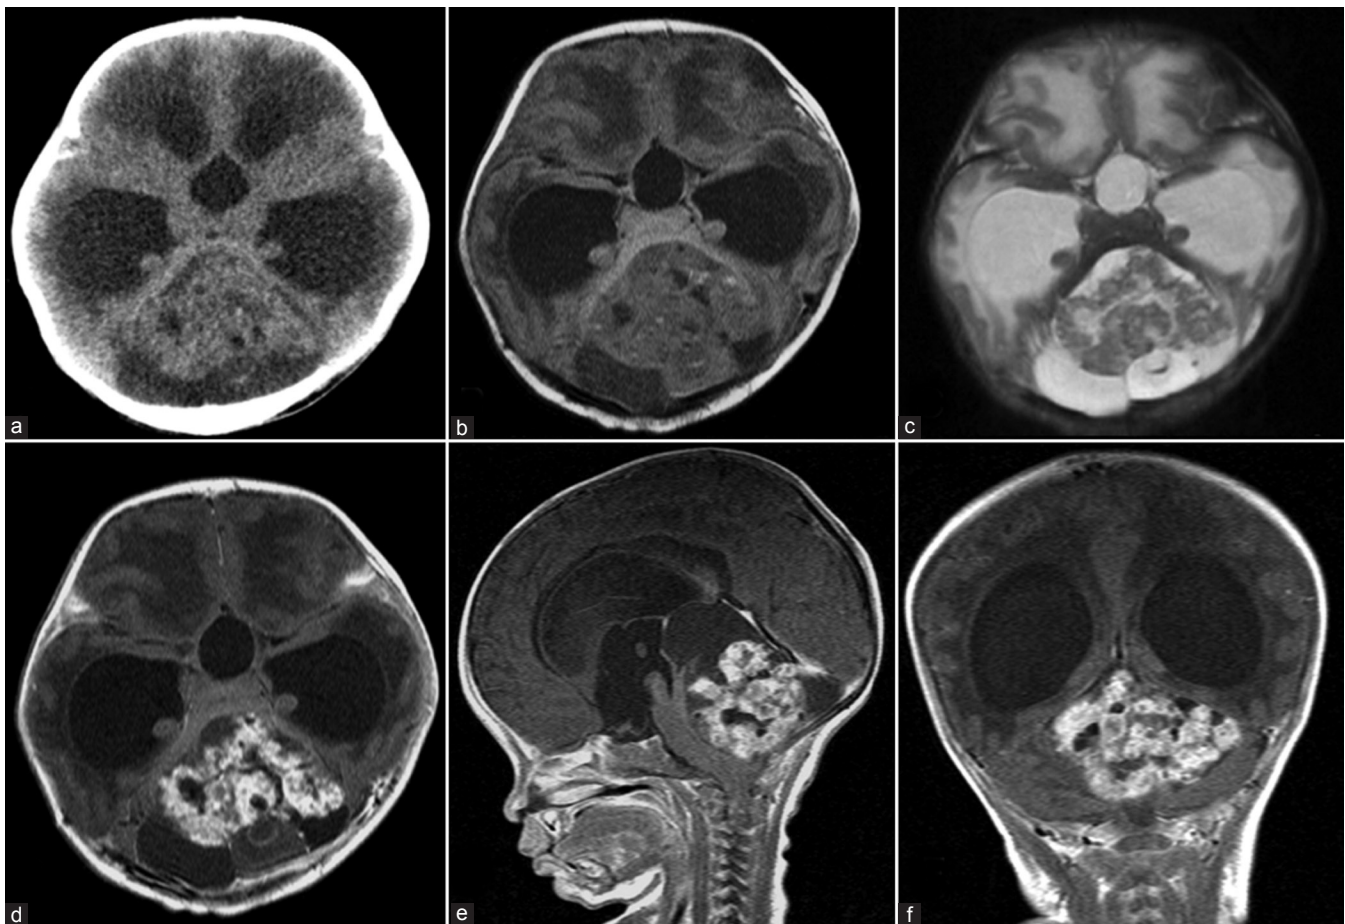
Preoperative computed tomography (CT) (a) showed a large tumor with inhomogeneous density compressing cerebellum. Hydrocephalus was present with periventricular lucency. It is also inhomogeneous and multiloculated on T1-weighted (b) and T2-weighted (c) magnetic resonance images (MRIs). Gadolinium enhanced MRI (d-f) showed heterogeneous enhancement effect
